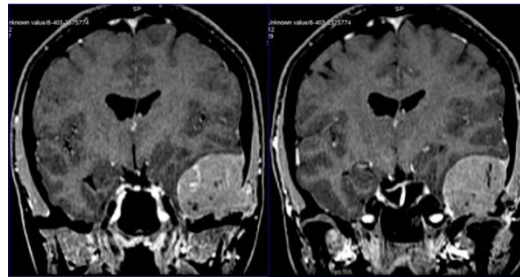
Brain MRI: T1, T2, and FLAIR sequence showing the expansive lesion and the bone involvement.
